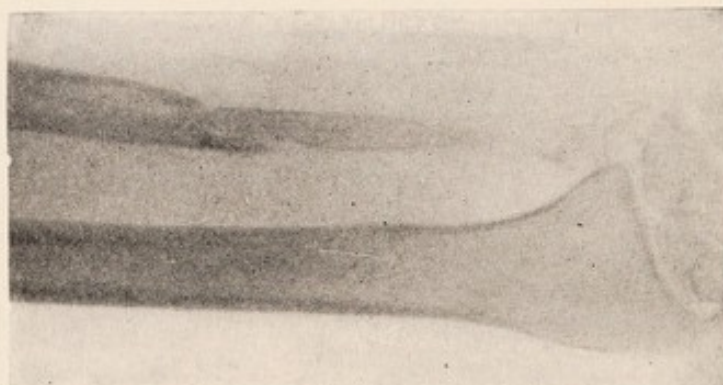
Roentgenogram showing destruction of portion of ulna and soft parts, with bone-graft (tibia) *in situ*.
